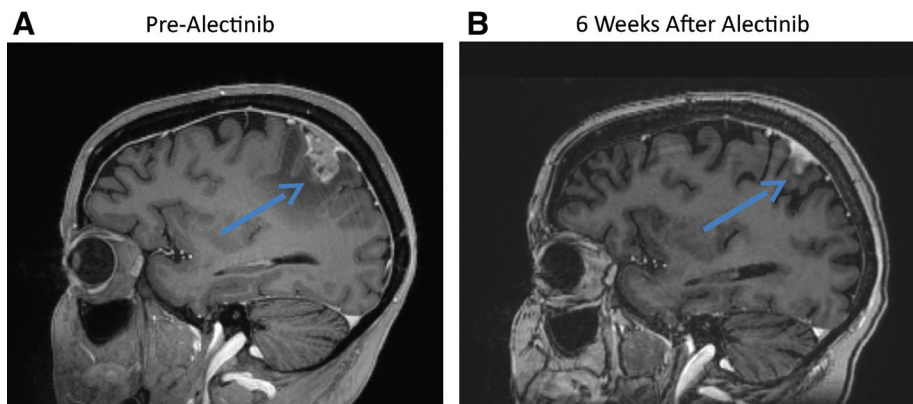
Regression of a nodular leptomeningeal metastasis in an ALK-positive patient treated with alectinib. Sagittal, T1 post-gadolinium magnetic resonance images *A*, before treatment with alectinib (*blue arrows* abnormal, nodular leptomeningeal enhancement) and *B*, 6 weeks after starting alectinib.
